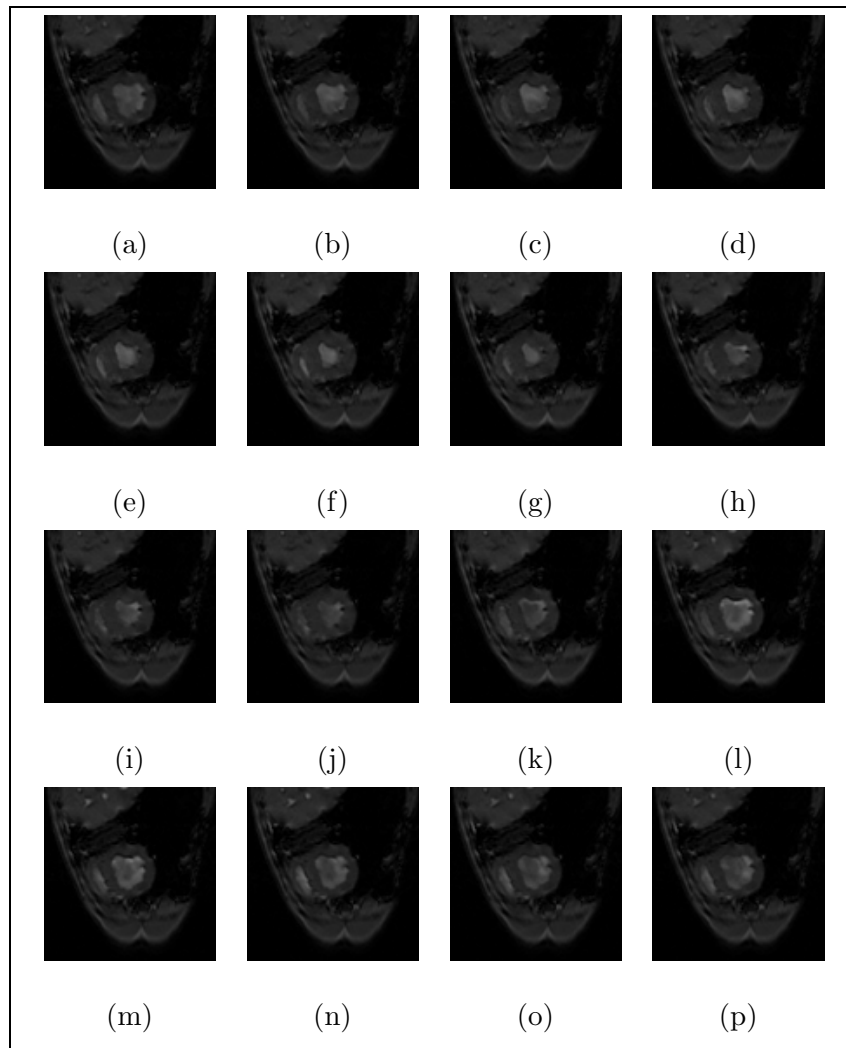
Sixteen temporal MRI images of a mid-ventricle slice. The images run from top to bottom, left to right for the temporal sequence of ED to ES to ED.
